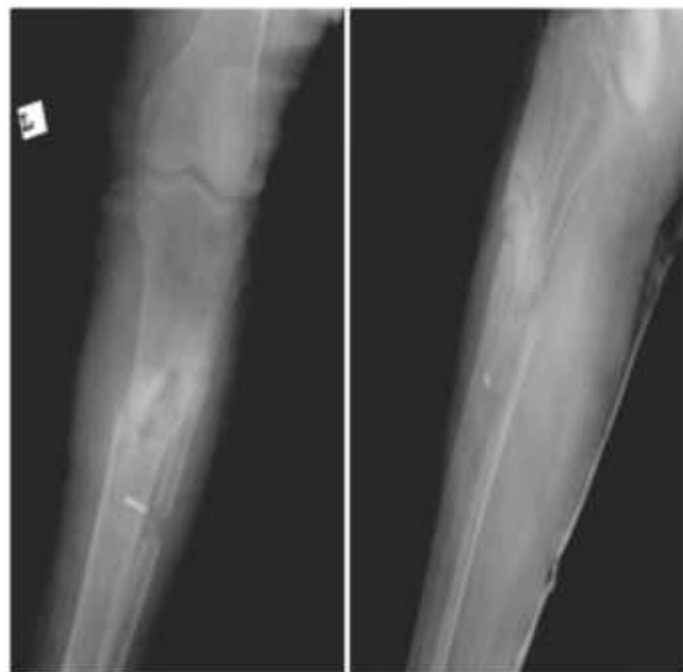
Pre-op x-ray of Patient G.N.
